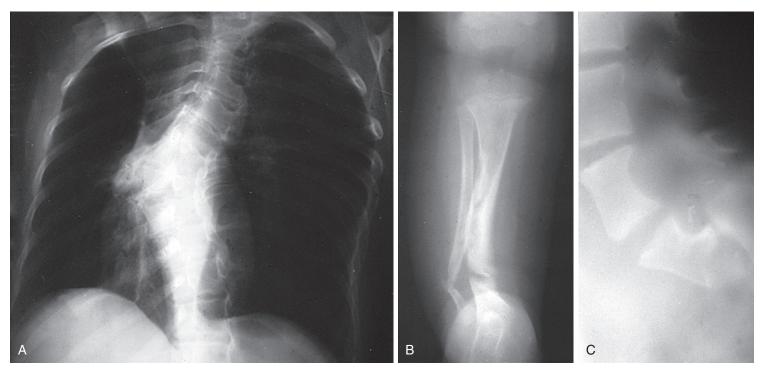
Neurofibromatosis 1 (NF-1). Radiographic manifestations of skeletal abnormalities. A, Severe angular scoliosis and vertebral dysplasia. B, Congenital bowing and pseudarthrosis of the tibia and fibula. C, Scalloping of the posterior margins of the vertebral bodies resulting from dural ectasia. (*Courtesy Department of Radiology, Children's Hospital of Pittsburgh, Pittsburgh, Pa.*)
